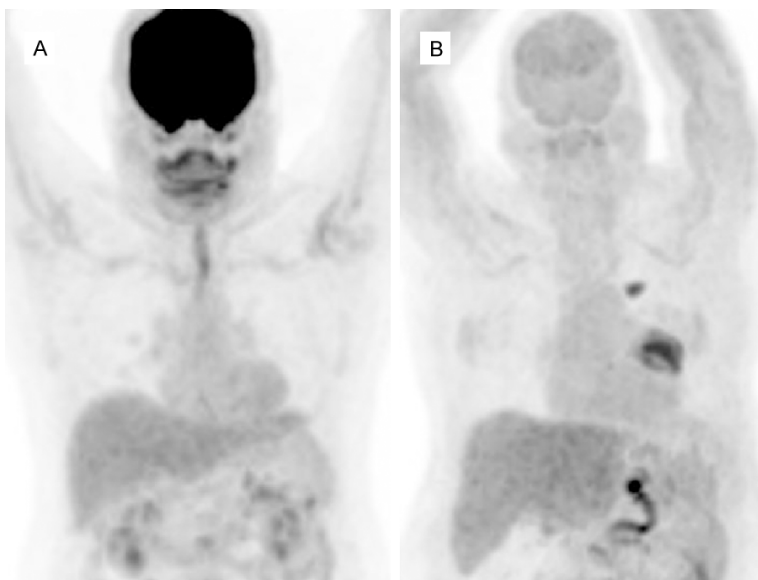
FDG PET MIP images in normoglycemic (6.2 mmol/dl) (A) and hyperglycemic (14 mmol/dl) (B) patients. Both visually and semiquantitatively, liver activity appears to be similar in both cases which is higher than blood pool and splenic activity. SUVmax/SULmax in normoglycemic and hyperglycemic patients were 3.9/2.3 and 4.3/2.2, respectively. Also note the markedly decreased uptake in the brain due to hyperglycemia with no significant effect of hyperglycemia on liver activity. There is also a hypermetabolic lung tumor in the left hilar region with a metastatic focus superior to it (B).
